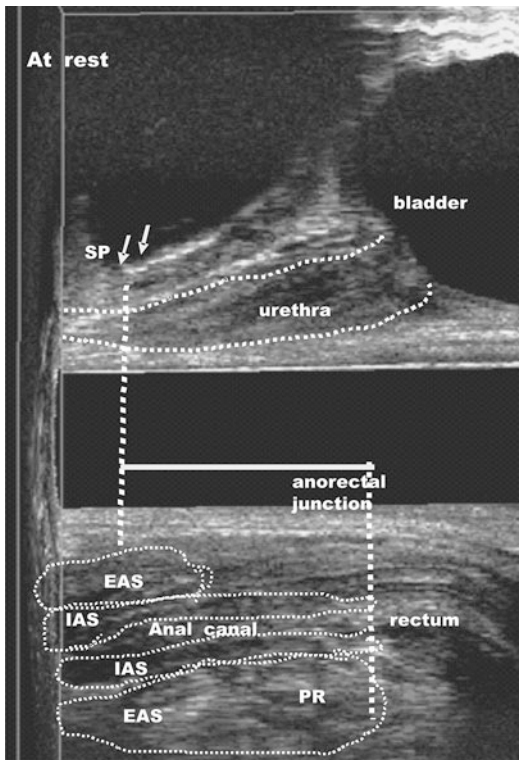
3-D endovaginal ultrasound. Measurements of the anorectal junction position. *IAS* internal anal sphincter, *LM* longitudinal muscle, *EAS* external anal sphincter, *PR* puborectalis muscle, *SP* symphysis pubis
